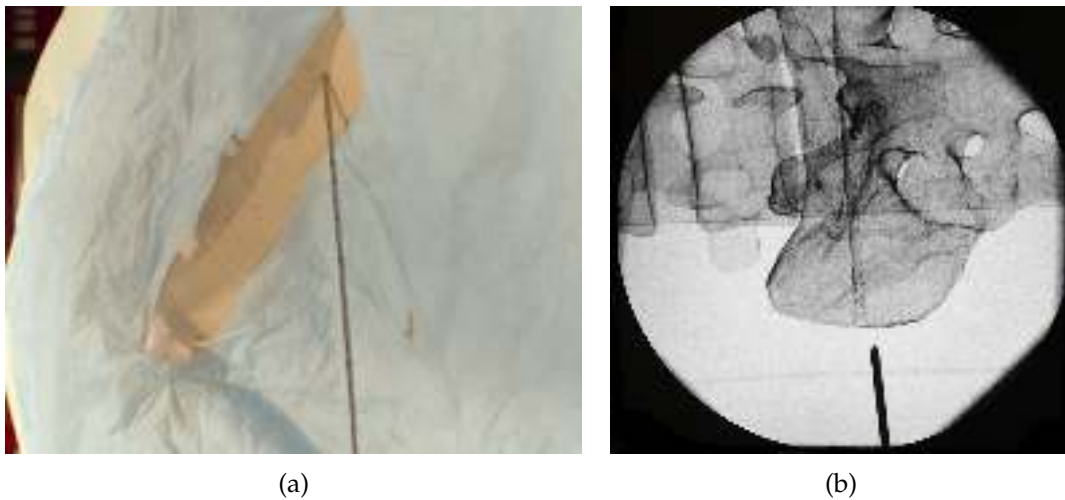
In a minimally invasive orthopedic procedure, surgeons are trying to locate the entry point and determine the insertion angle with the help of X-Ray imaging. (a) shows the surgeon's view while (b) shows the X-Ray image. Surgeons are required to mentally align their view to the X-Ray image.
